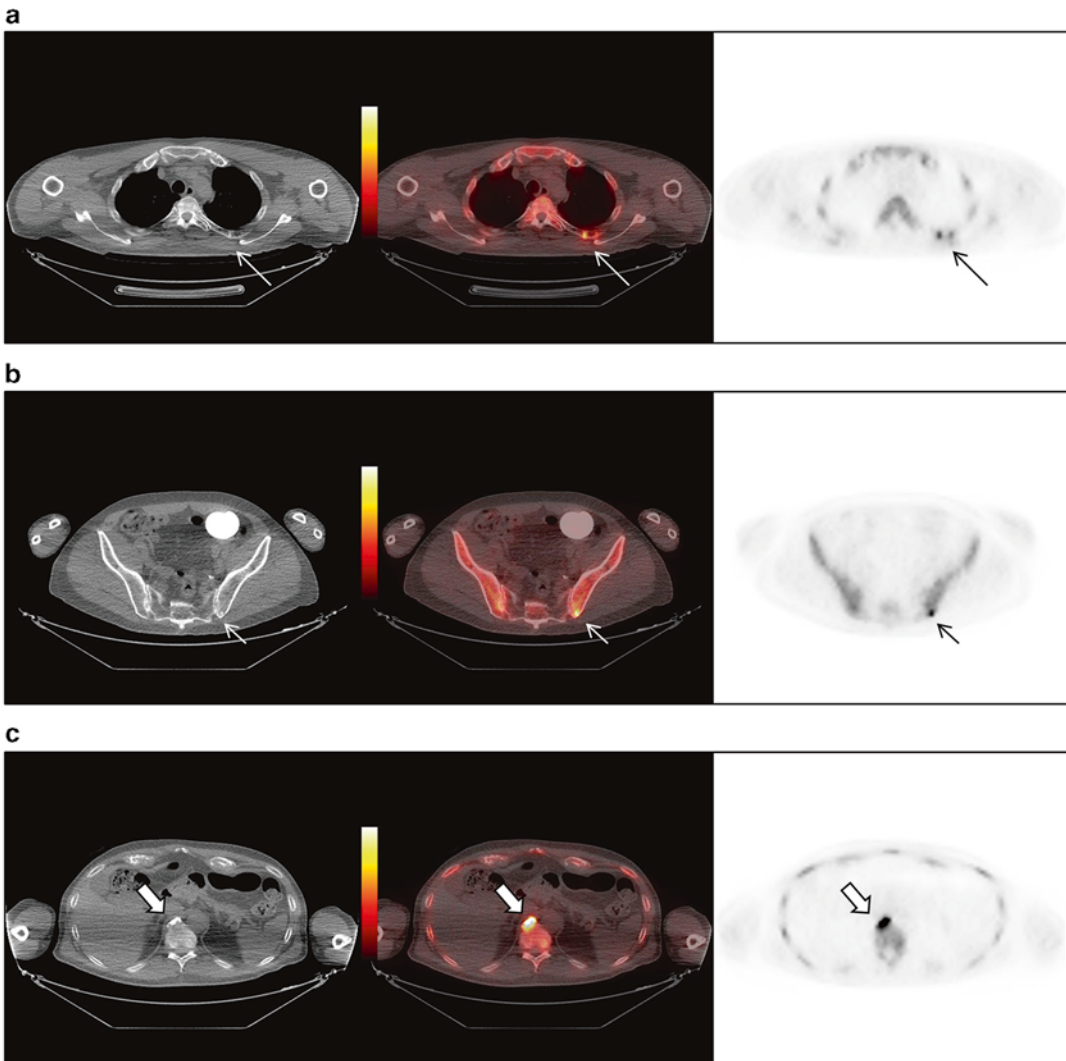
A 68-year-old male with bone metastases on NaF PET/CT involving the (a) left fourth rib (*long arrow*), (b) left posterior iliac bone (*short arrow*), and (c)
